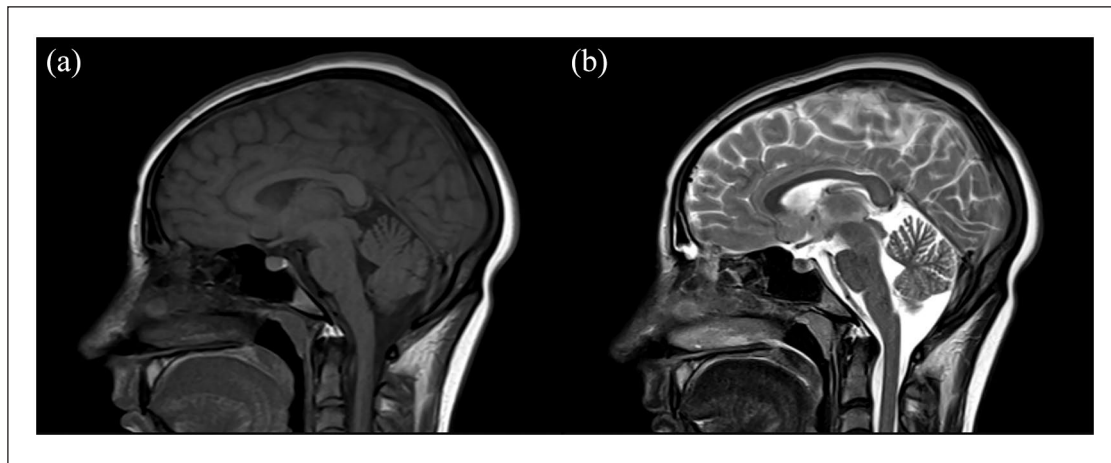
Magnetic resonance (MR) images of Case 2 (22-year-old female with isolated splenium infarct after COVID-19 infection). Sagittal T1-weighted image (a) shows no pathological signal in splenium; however, sagittal T2-weighted images indicate the focal hyperintensity of the splenium (b).
